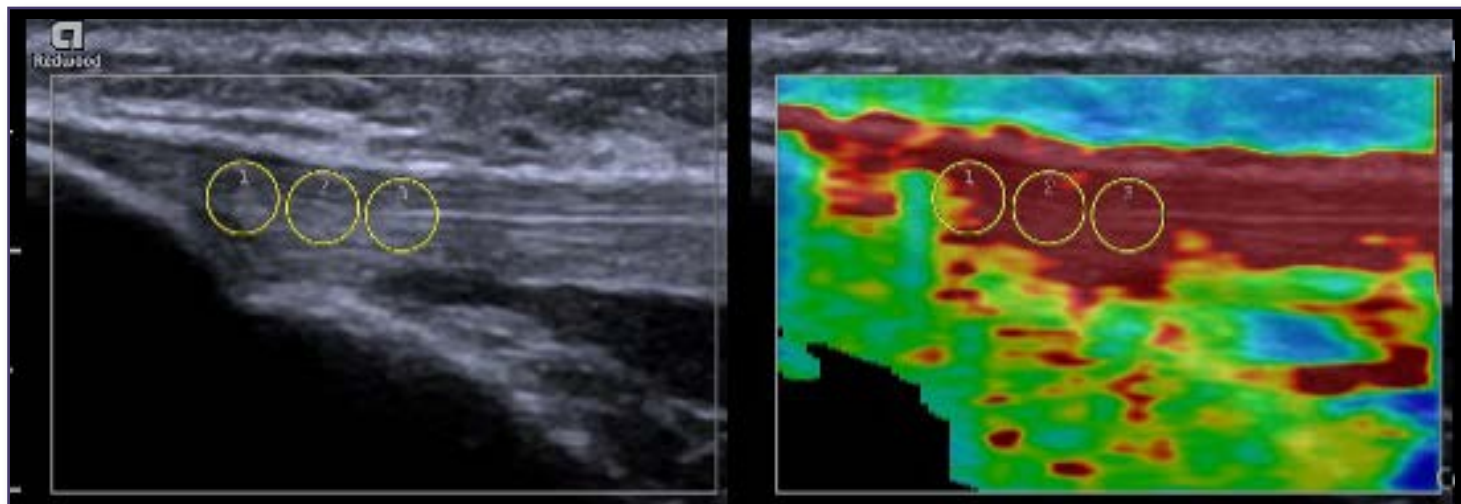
Ultrasound image (ACUSON Redwood Ultrasound System, Siemens Medical Solutions USA, Inc., Issaquah, WA) of the length of the patellar tendon. There are 3 locations where clinicians may choose to measure the thickness of the patellar tendon (proximal, middle, distal). Thickening of the tendon is a common pathological sequelae of patellar tendinopathy, particularly at the inferior pole of the patella.
